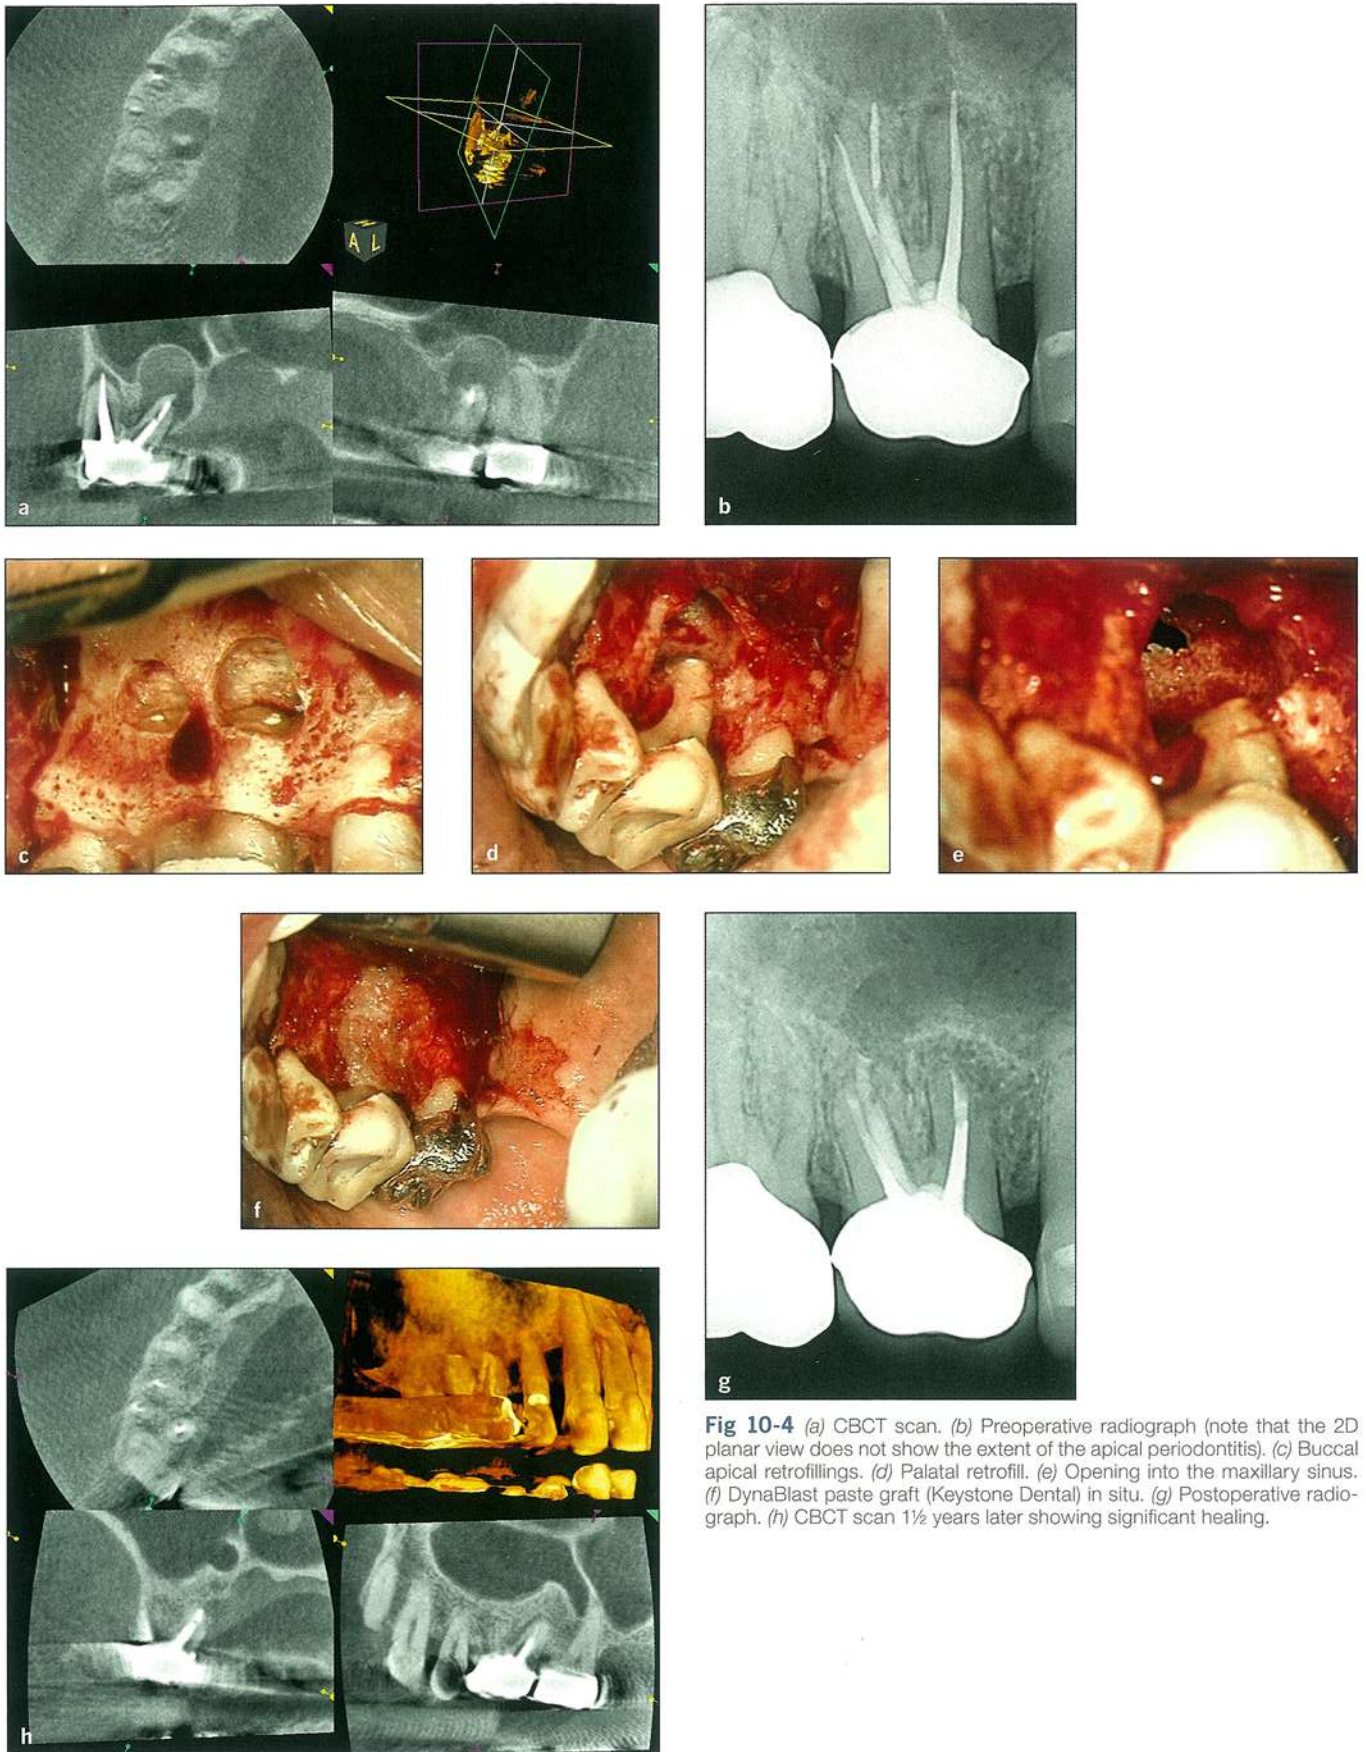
(a) CBCT scan. (b) Preoperative radiograph (note that the 2D planar view does not show the extent of the apical periodontitis). (c) Buccal apical retrofillings. (d) Palatal retrofill. (e) Opening into the maxillary sinus. (f) DynaBlast paste graft (Keystone Dental) in situ. (g) Postoperative radiograph. (h) CBCT scan 1½ years later showing significant healing.
